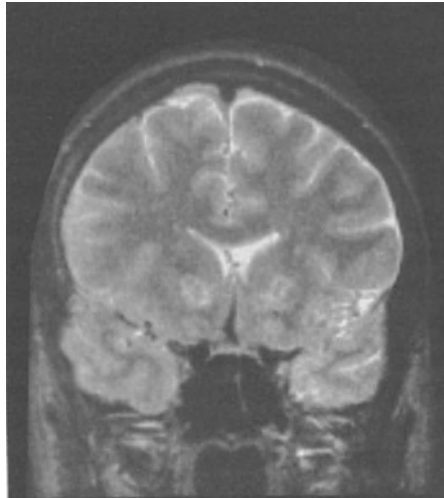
Gamma Knife capsulotomy for anxiety neurosis. Coronal T2-weighted MRI image in a patient subjected to bilateral capsulotomy using the Gamma Knife. Three months follow-up with the lesions visible in the anterior internal capsule both right and left
